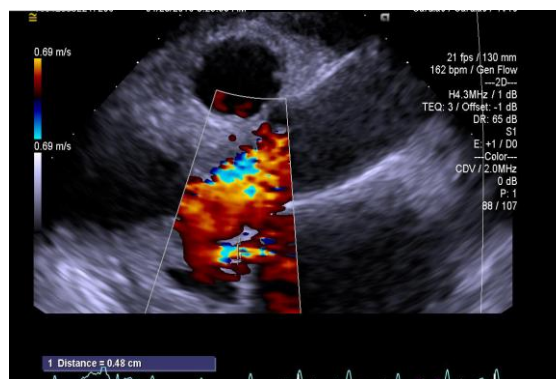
Trans esophageal echocardiography severe AI
